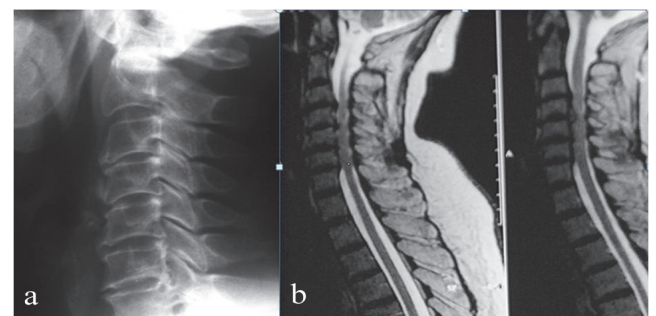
Preoperative radiograph of a 62-year-old female patient with radiculopathy shows disc space narrowing (a), and sagittal preoperative T2 Weighted MR image discerns cervical 3-4,4-5,5-6,6-7 spondylosis and anterior spinal cord compression (b).
